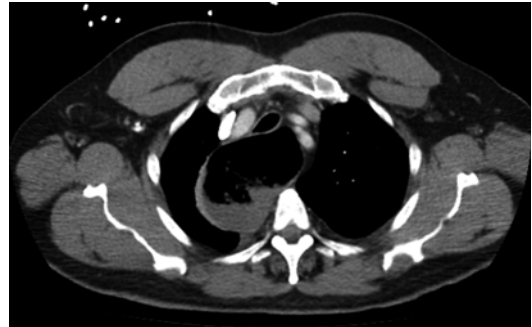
CT scan. Dilated esophagus
